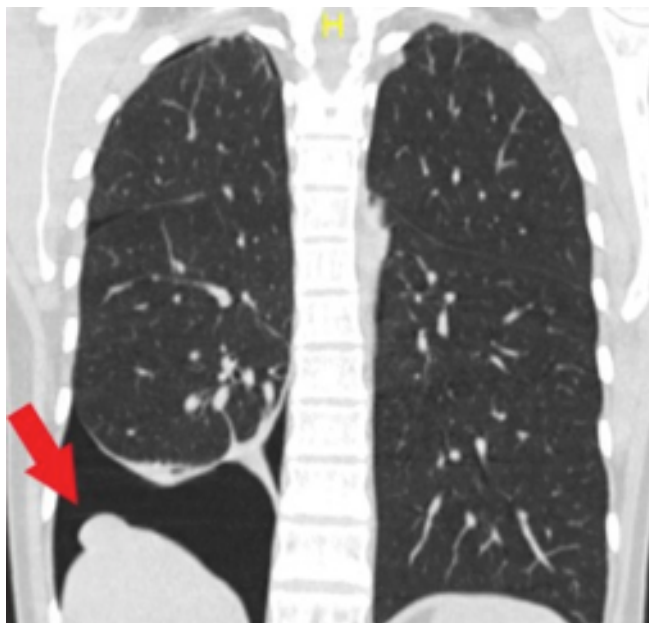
Thoracic CT coronal section image showed focal herniation of the right lobe of the liver from the diaphragmatic defect.
